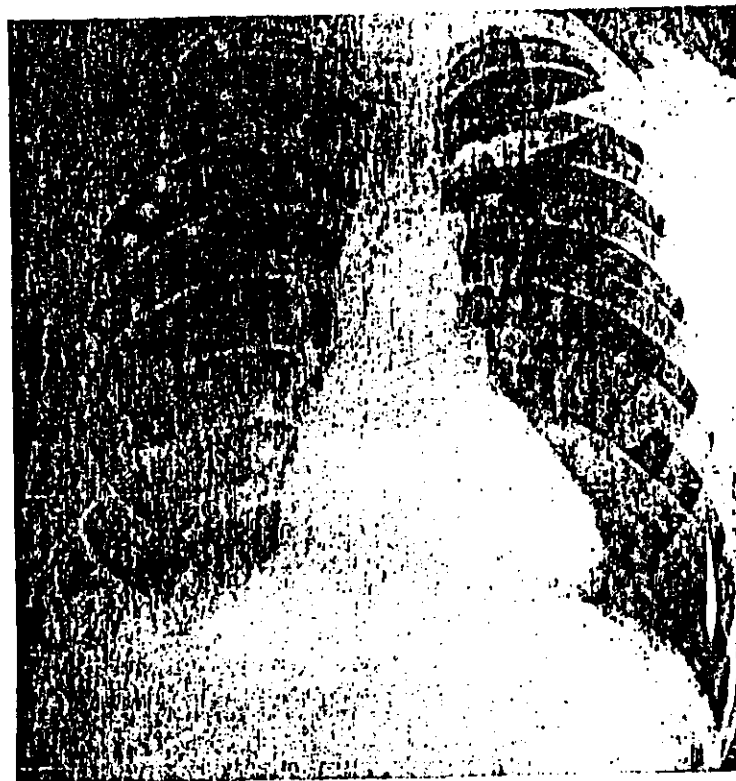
CHEST X-RAY OF CASE H-23 15 MONTHS BEFORE DEATH.
